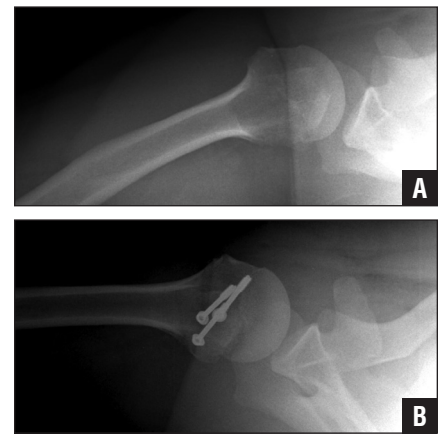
Preoperative axillary radiograph of the right shoulder in an 18-year-old right-hand-dominant man showing a displaced isolated greater tuberosity fracture where the greater tuberosity fragment is unusually large, with 36 mm of superior displacement (A). Postoperative axillary radiograph after open reduction and internal fixation using partially threaded cannulated screws showing anatomic reduction of the fracture (B).
